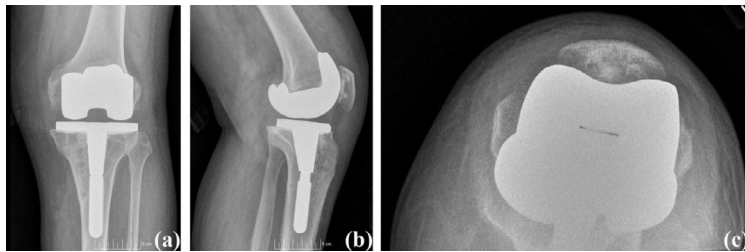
Case #3 post-operative radiographs: (a) anterior posterior view, (b) lateral view, and (c) sunrise view.
